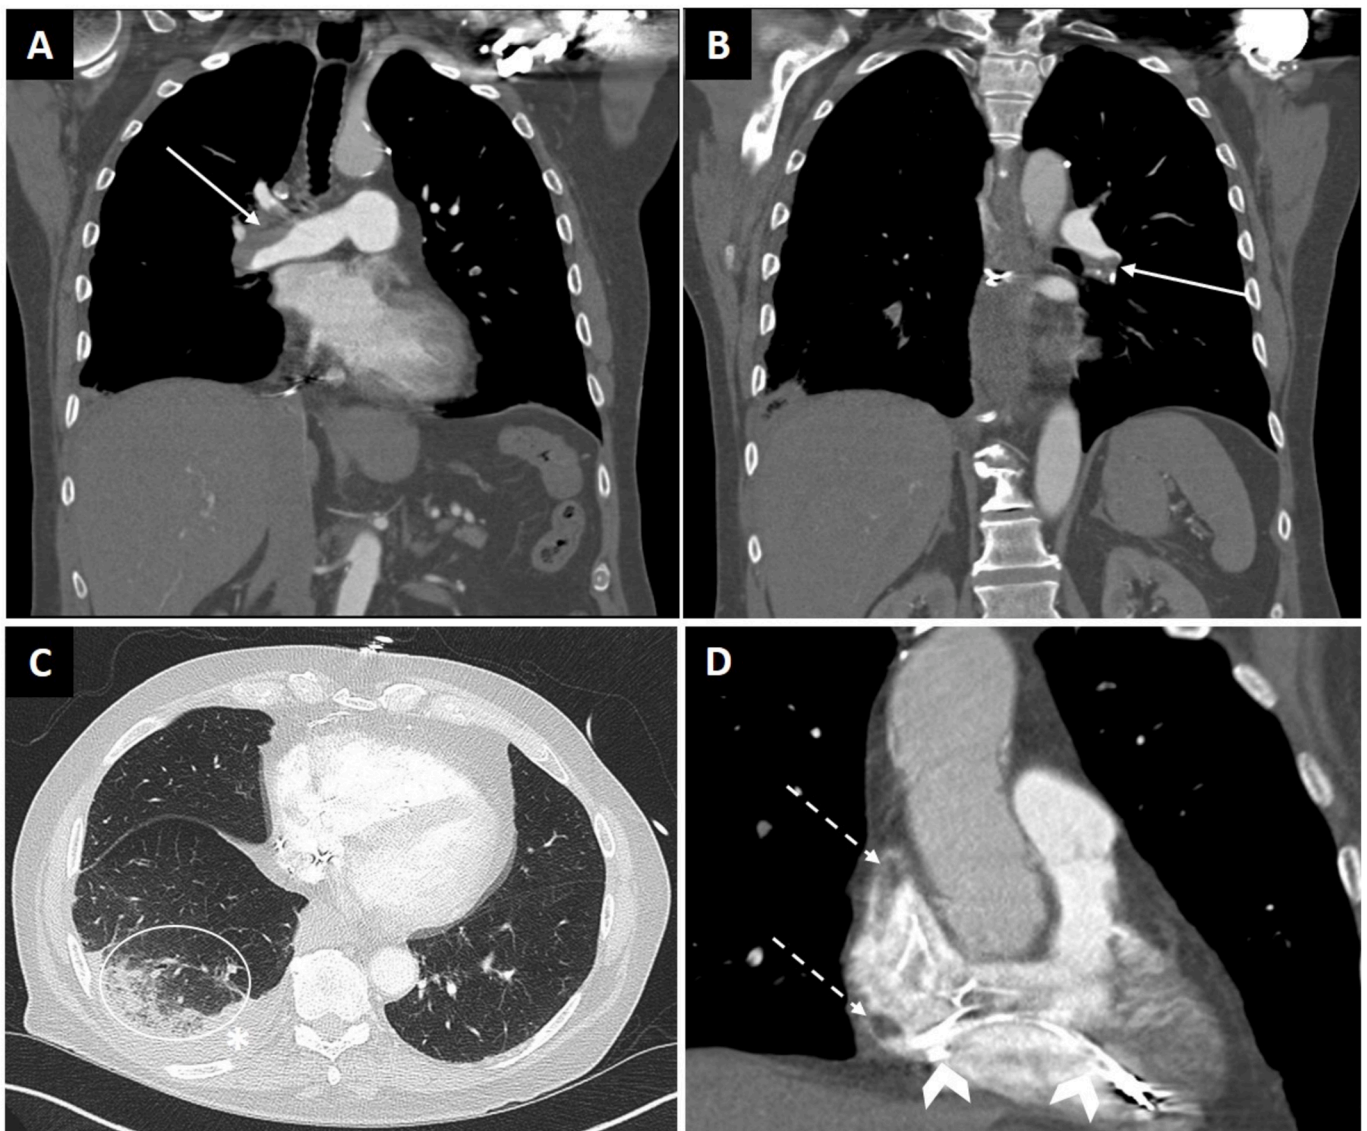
Computed Tomography Angiogram (CTA) of the Chest with Acute Pulmonary Embolus and Pacemaker Lead-Associated Thrombus. A, B: Coronal views in soft tissue window demonstrate nearly occlusive acute bilateral central pulmonary emboli (solid arrows). C: Axial view in lung window shows a developing right lower lobe infarction (circle) and small pleural effusion (asterisk). D: Zoomed in coronal image of the heart (soft tissue window) demonstrates a filling defect extending into the right atrium from the superior vena cava (dashed arrows), which was thrombus associated with a pacemaker lead (chevrons). Consecutive images through the right atrium strongly suggested a continuous filling defect (thrombus) rather than multiple smaller thrombi, and was better characterized on echocardiography.
